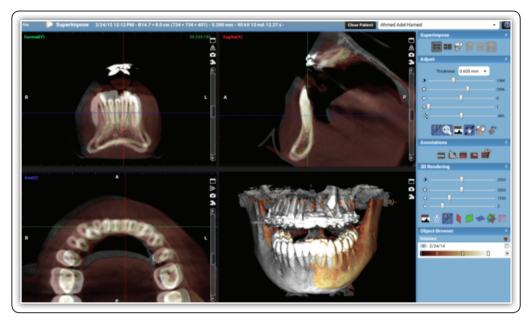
3D superimposition and manual refinement process of T1 and T2 CBCT images by targeting one mamdibular incisor based on its long axis and anatomical crown, that adjusted on axial, sagittal, and coronal planes.
